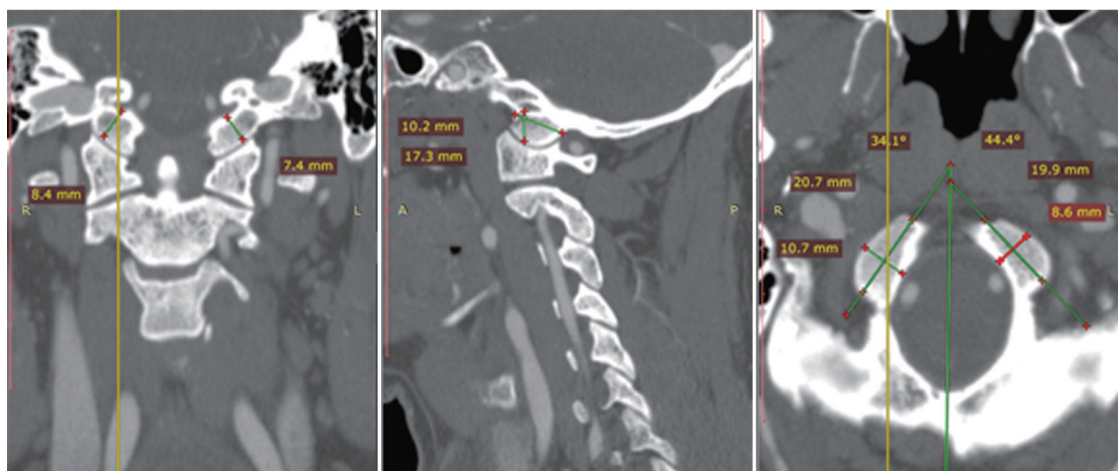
Coronal, sagittal, and axial computed tomography images with sagittal and coronal height, condylar width, screw angle, and screw length as measured in our study: example 1.
